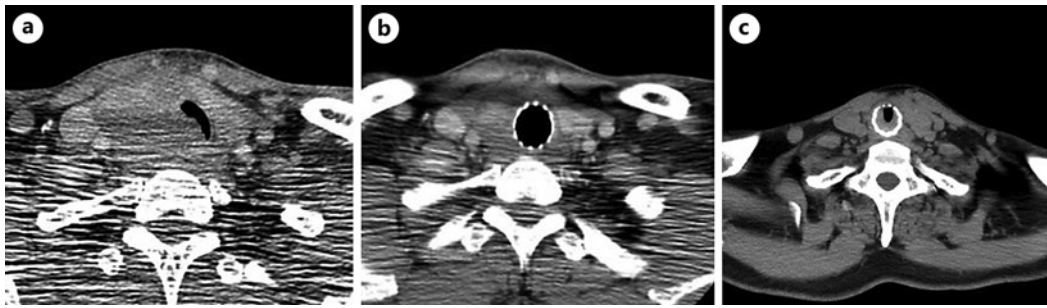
a Computed tomography (CT) revealed enlargement of the right lobe of the thyroid gland causing severe compression and stenosis of the trachea. b A metallic stent was placed in the trachea. The size of the thyroid gland is normalized after drug therapy for malignant lymphoma. c CT revealed severe stenosis of the metallic stent 8 years after treatment.
